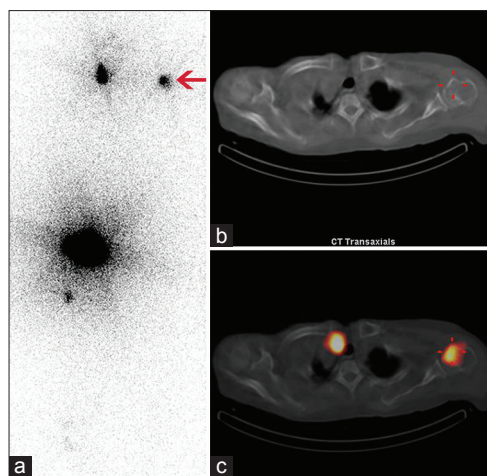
Pretherapy I-131 planar whole-body anterior view image (a) of a 65-year-old female patient with follicular thyroid cancer showed intense tracer uptake at the thyroid bed. Increased foci of tracer uptake were also noted in the left shoulder region (arrow), pelvic and right thigh region. Transaxial CT (b) and corresponding transaxial fused single photon emission computed tomography/computed tomography images (c) of the thorax localizes foci of tracer uptake to the thyroid bed and left humerus (cursor)
